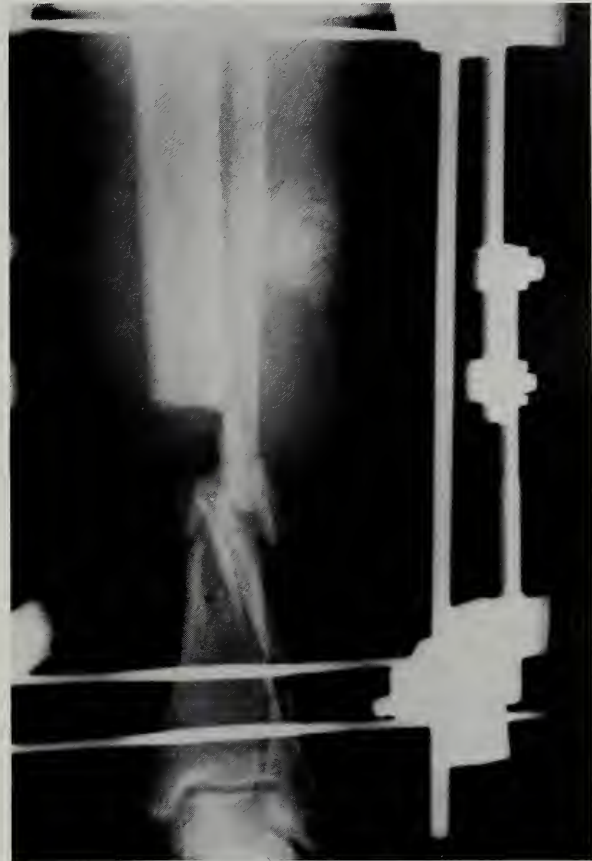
AP radiograph demonstrating bony defect.
